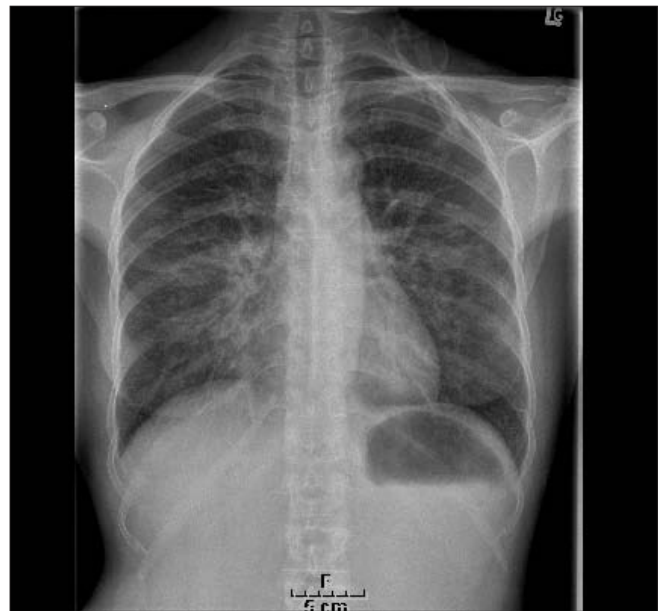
Results of the initial sitting anterior-posterior chest x-ray
